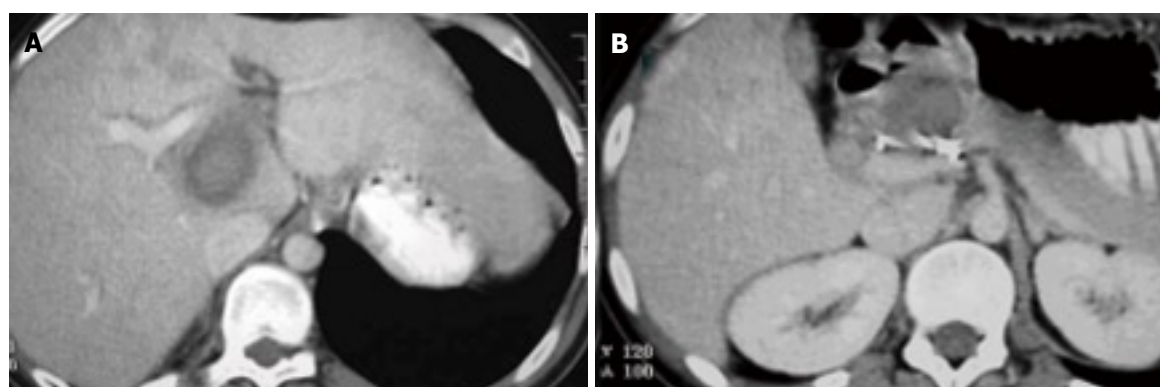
CT scan 12 mo after treatment. Complete thrombosis of the pseudoaneurysm and no dilation of the biliary tract are observed.
